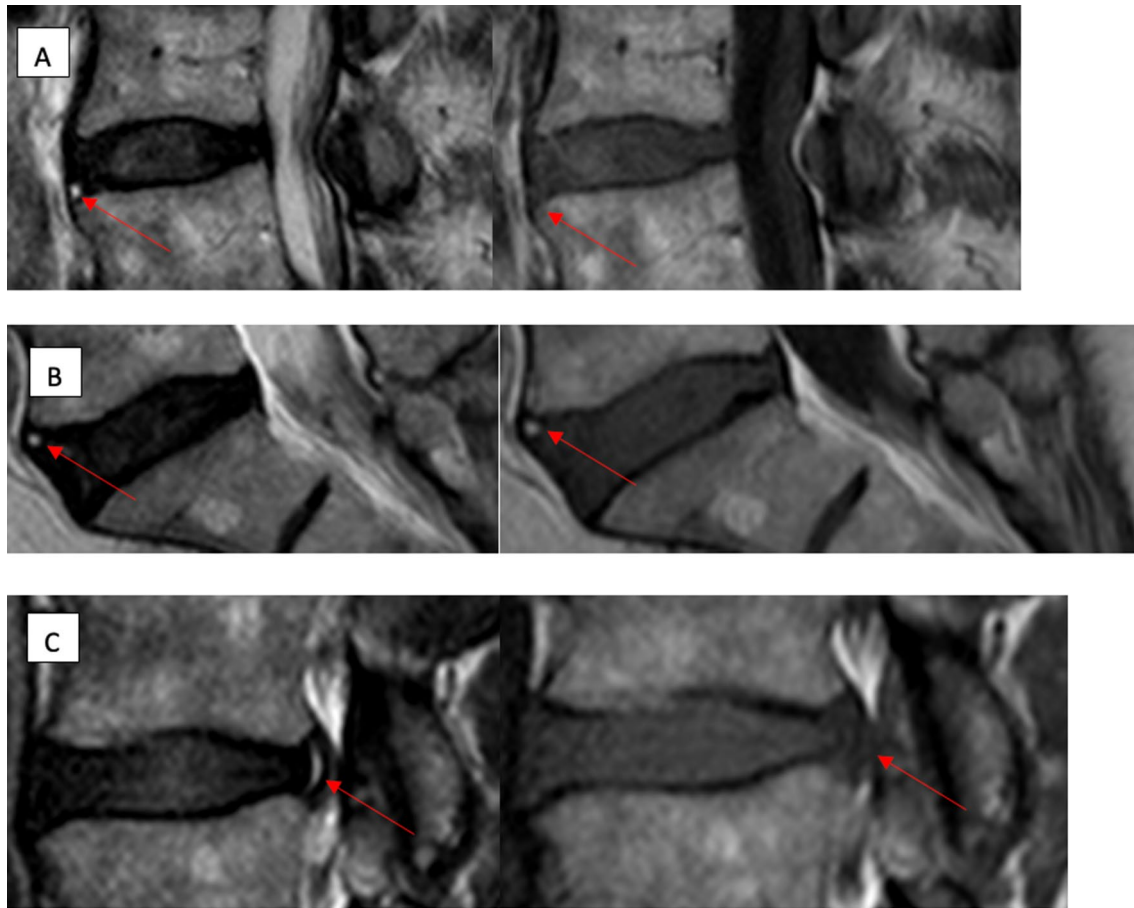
Example High Intensity Zones on T1 and T2-weighted Magnetic Resonance Imaging. A sagittal slice from the magnetic resonance imaging (MRI) of three different patients with high intensity zones (HIZ) with different T1-weighted MRI classifications. (a) Represents an anterior HIZ on T2W MRI with corresponding isointense
